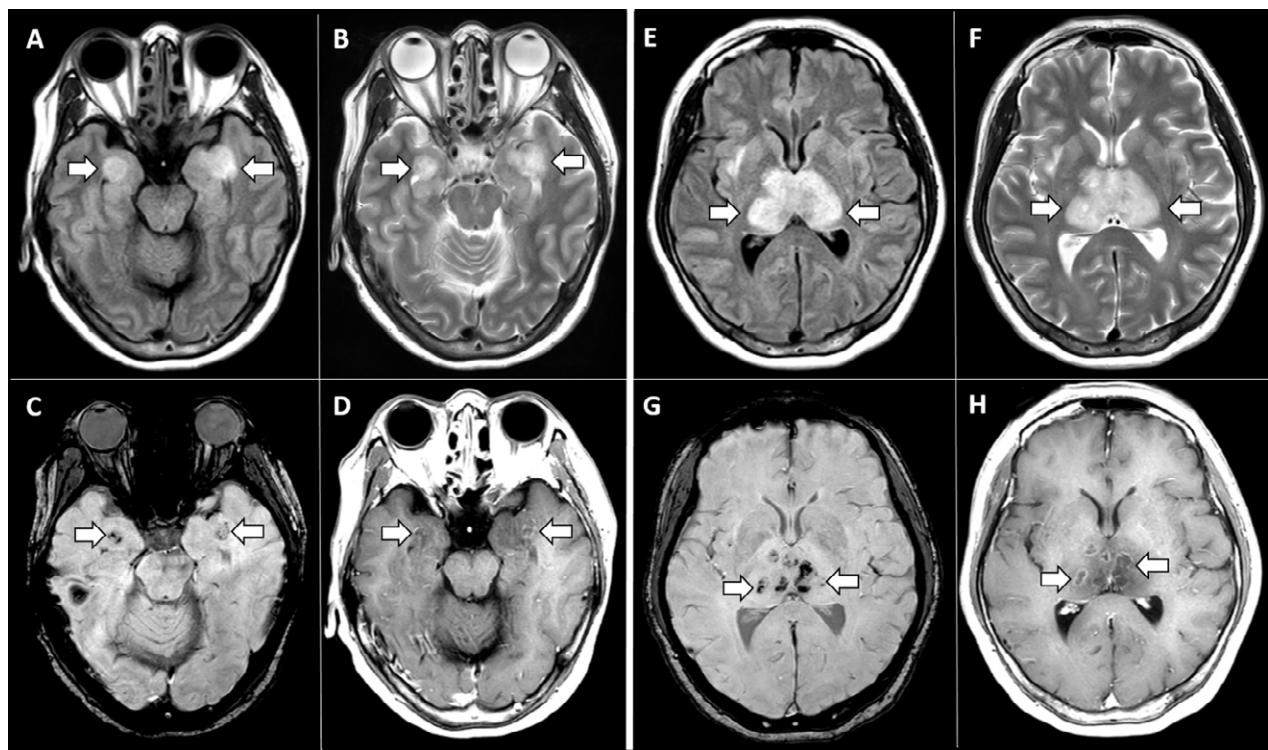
MRI images demonstrate T2 FLAIR hyperintensity within the bilateral medial temporal lobes and thalami (*A, B, E, F*) with evidence of hemorrhage indicated by hypointense signal intensity on susceptibility-weighted images (*C, G*) and rim enhancement on postcontrast images (*D, H*).
